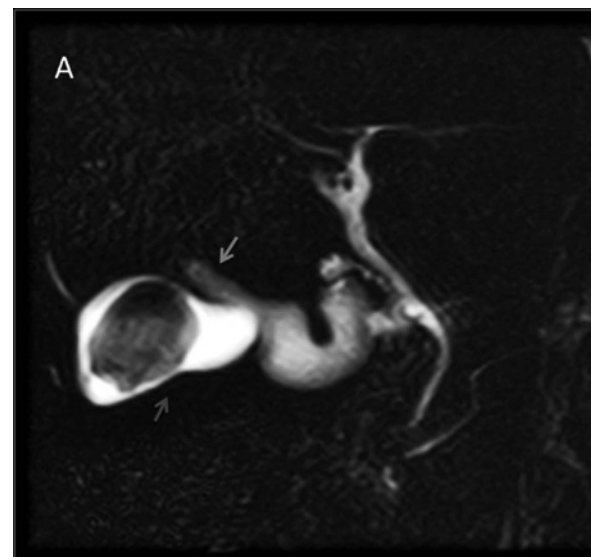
“Y” gallbladder configuration. Magnetic resonance imaging cholangiogram performed as a presurgical study to rule out choledocholithiasis in a middle-aged woman with US gallstone diagnosis. The US showed no subtle abnormalities other than gallstones. Three-dimensional MRI cholangiogram depicts 2 independent gallbladders (arrows) with a common infundibulum and cystic duct.
